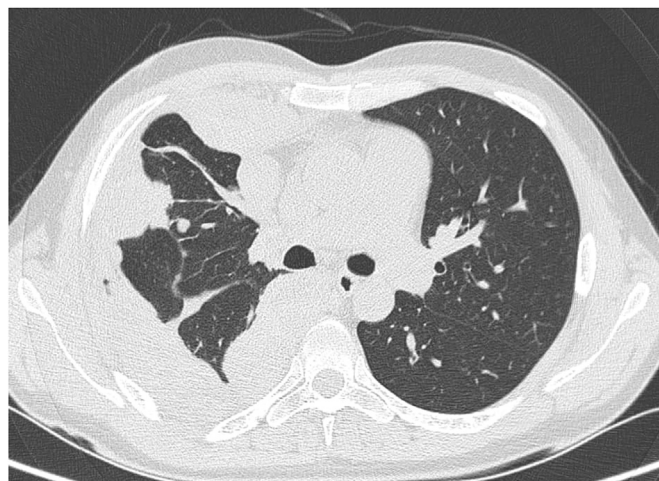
Computed tomography scan (axial view) showing multiple pleural based lobulated masses suspecting mesothelioma.
